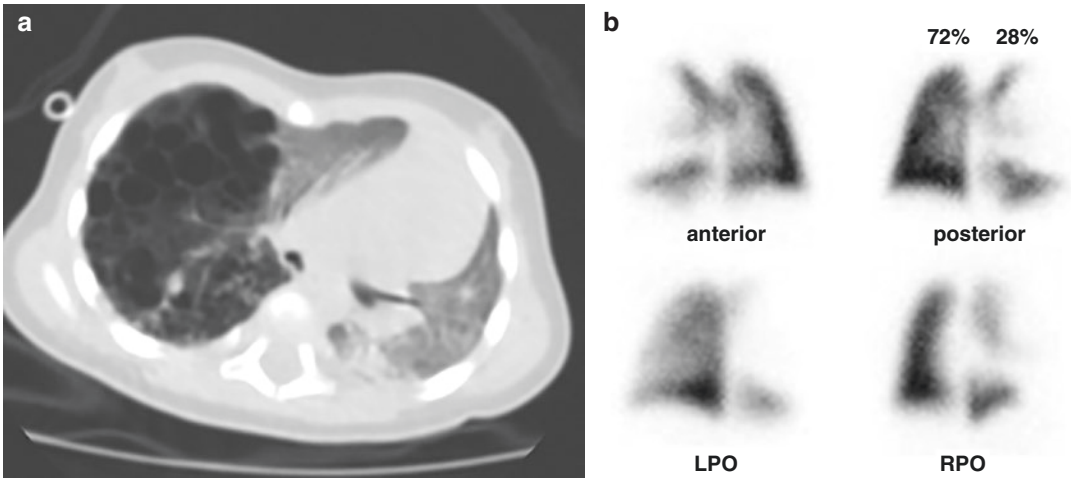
History: A 4-month-old girl with a large congenital cystic adenomatoid malformation of the right lung as seen on chest CT (a). Study report: Baseline perfusion lung scintigraphy (b) shows a large perfusion defect in the right lung corresponding to the malformation. The differential perfusion was: right lung 28%, left lung 72%.
